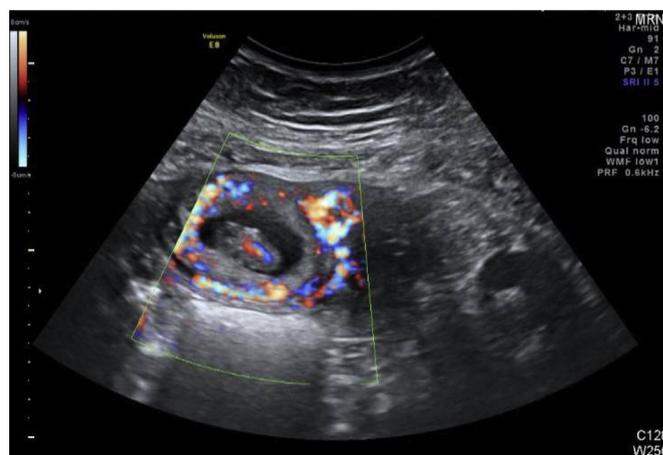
The 2D Doppler US indicated a colorful vascular ring which had sufficient blood supply.
